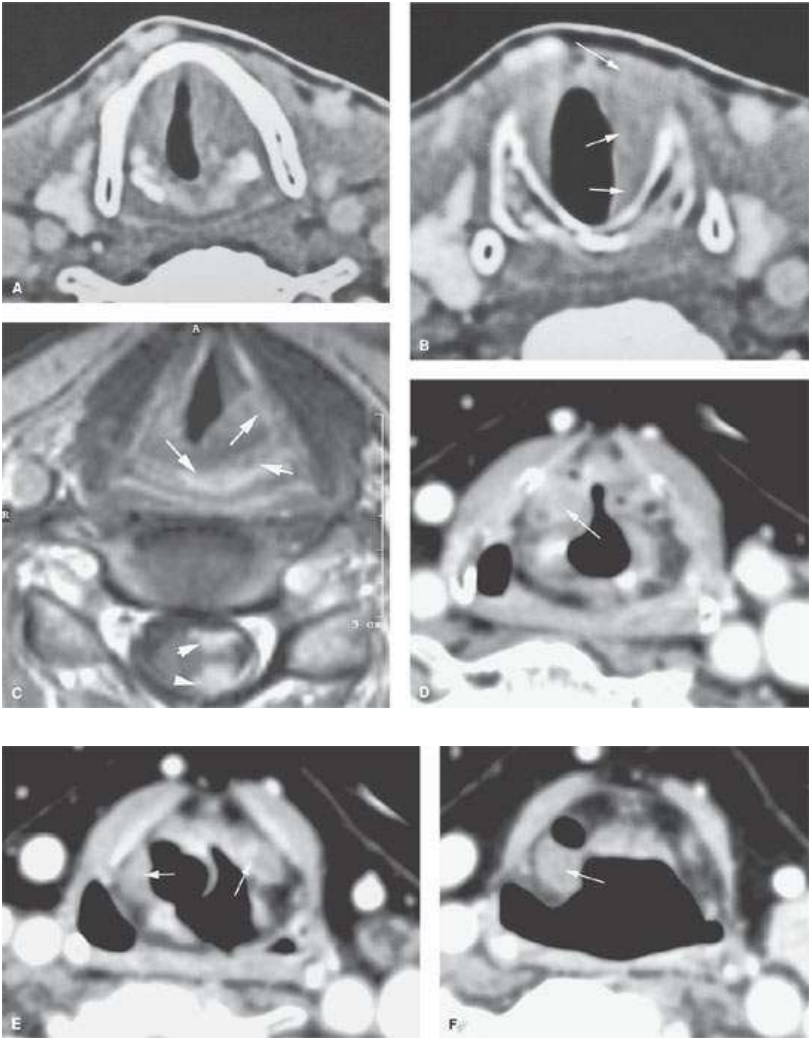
Three patients with laryngeal lymphoma A, B: In Patient 1 the lymphoma is confined to the glottic and subglottic levels and is indistinguishable from SCCa. C: MRI of Patient 2 with CNS disseminated non Hodgkin's lymphoma the CE T1W image correlating showing pia-arachnoid “caking” of the spinal cord (arrowheads) and spread to the arytenoid pad of the posterior laryngeal wall (arrows). D–F: Patient 3 had predominantly multifocal (arrows) supraglottic disease with involvement of the false cord and aryepiglottic folds. (continued)
